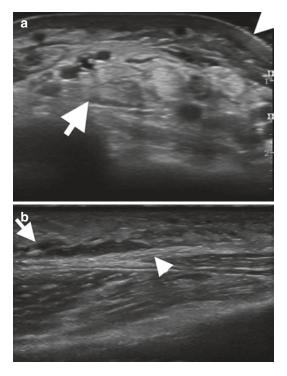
(a) Ultrasound in a patient with lower-limb cellulitis with subcutaneous thickening of heterogeneous echotexture. Doppler, not shown, would demonstrate increased flow. (b) A 73-year-old female presenting with superficial peroneal nerve (SPN) symptoms and panniculitis (*arrow*) on ultrasound with irritation underlying SPN (*arrowhead*)
